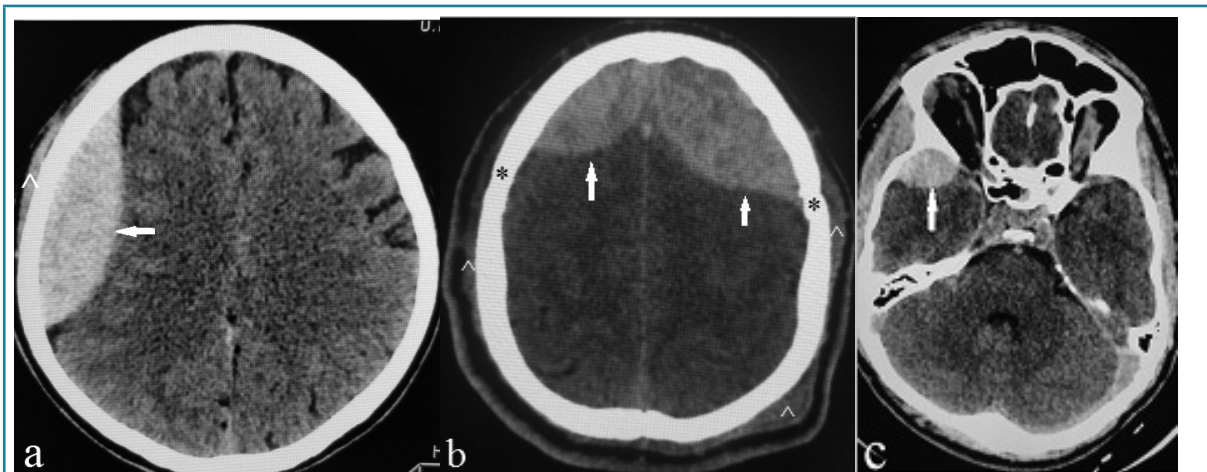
Different types of EDH (arrow) in axial non-contrast CT images. (a) Extra-axial biconvex (lenticular) hyperdense collection consistent with classic EDH from injury of middle meningeal artery or its branches in 23 years old male after RTA. It was associated with a fracture (not shown). (b) Bi frontal EDH in a 19 years male following fall injury. EDH crosses midline but limited by coronal suture (*). No fracture was identified. Source of bleeding is likely from injury of anterior sagittal sinus. (c) Anterior temporal EDH in 22 years old male following RTA. No fracture was identified. This EDH could be due to injury of sphenoparietal sinus or its major draining veins. Subgaleal hemorrhage (^)
